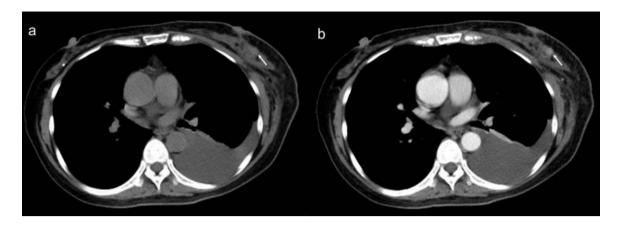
(B): Axial unenhanced (a) and contrast-enhanced (b) CT scans showed an irregular enhancing lesion with indistinct margins in breast on left side.
